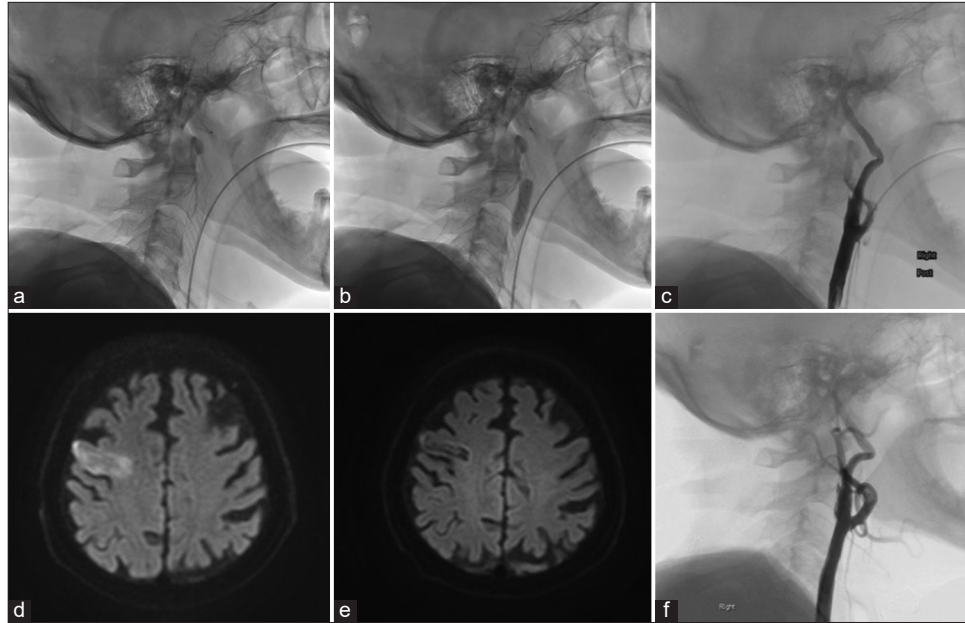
Intraoperative findings of CAS. (a) Full deployment of a CASPER stent. (b) Post dilation. (c) Postoperative DSA. No acute in-stent occlusion or plaque protrusion is observed. (d) Postoperative MRI. No ischemic complications are observed. (e) MRI 6 months after treatment. No new infarction is observed. (f) DSA 6 months after treatment. No in-stent stenosis is observed.
